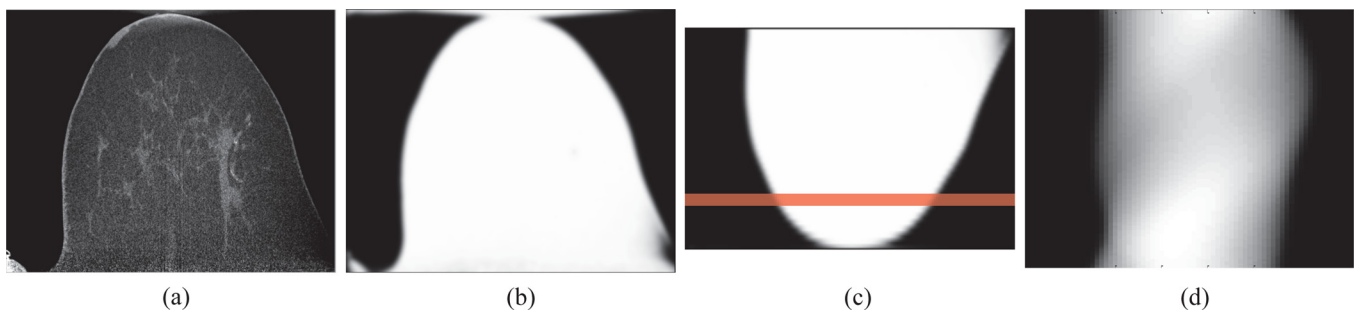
CT based ACF estimation for a patient image set. (a) The original CT image, (b) the segmentation of (a) to a uniform linear attenuation value and resolution matched to the PET, (c) the registration of (b) to the PET reference frame, and (d) the forward projection of (c) into sinogram space. The line in (c) denotes the approximate coronal slice for which the sinogram in (d) corresponds.
